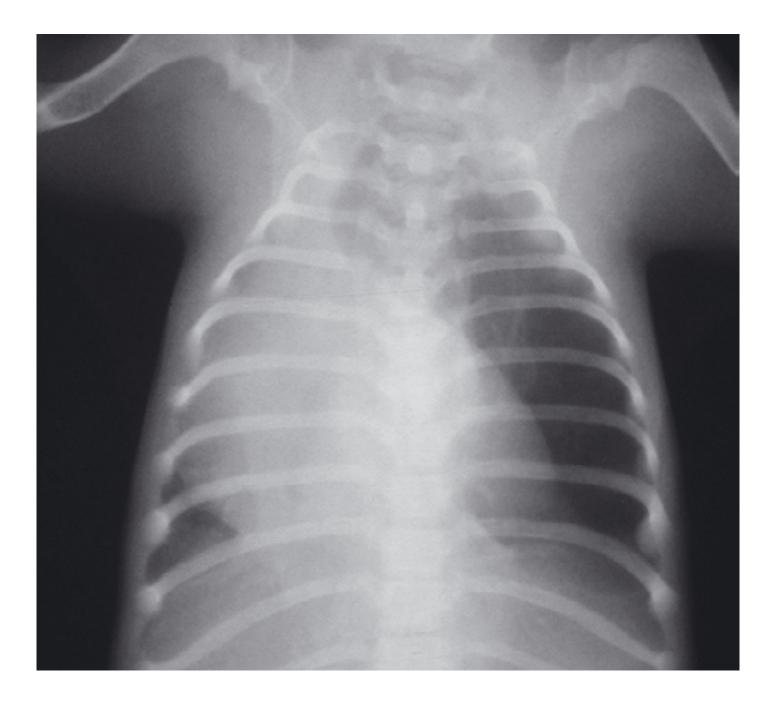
A dorsoventral chest x-ray of an eight-week-old pup with PPDH. Note that the cardiac silhouette is very large, is incompletely separated from the diaphragm and has sharp margins.
